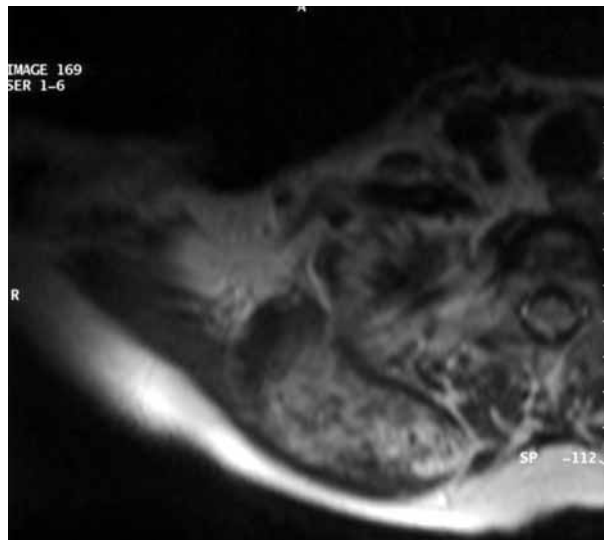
Axial T1-weighted magnetic resonance (MRI) image of the neck showing a soft tissue mass anterior to the trapezius muscle. This mass shows a signal intensity pattern similar to that of the subscapular lesions.
